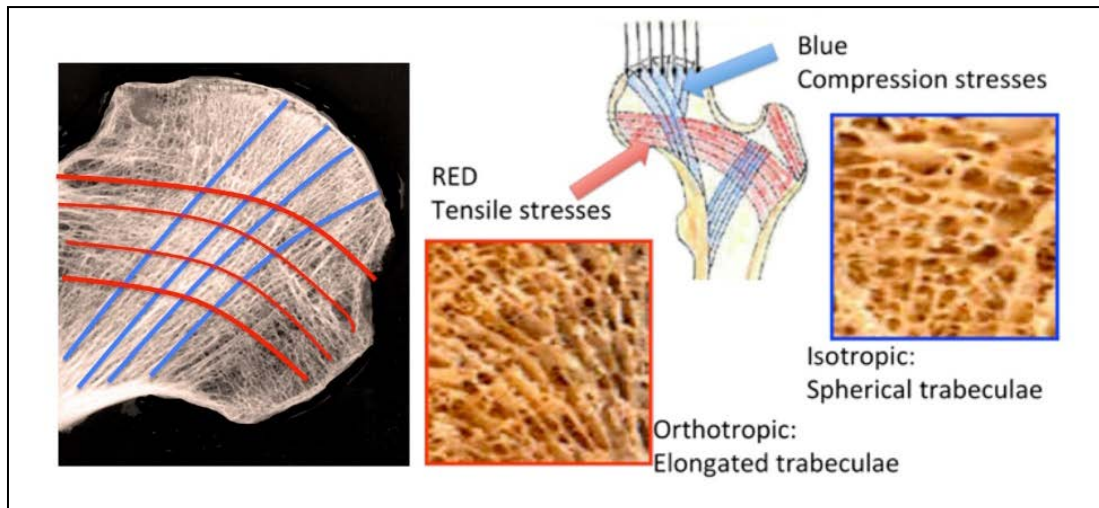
Radiographic evidence of oriented trabecular structure in compression (blue lines) and tensioned (red lines) and trabeculae isotropic (compression) and orthotropic (tension) morphology
